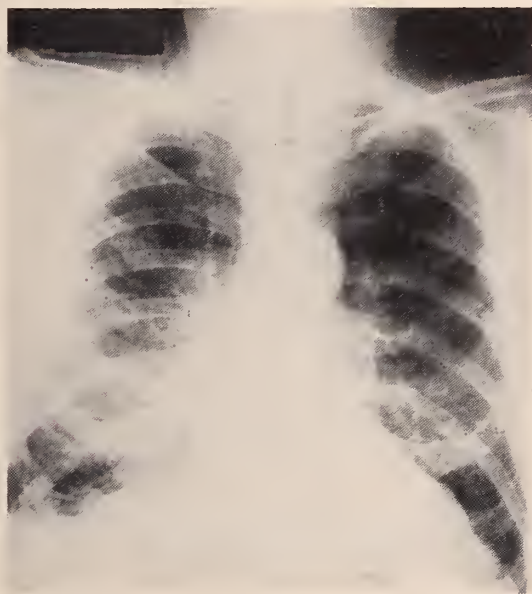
Roentgenogram, March, 1968, showing clearing of parenchymal infiltrates. Septal and fibrotic changes on right attributed to thoracotomy.
